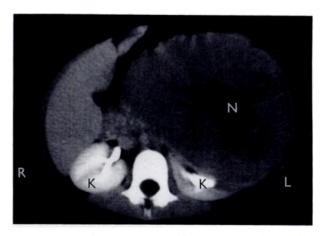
Computed tomography of the abdomen of a 5-year-old boy who has Wilms tumor. There is almost complete obliteration of the upper pole of the left kidney (K) by a large mass, apparently originating from this site. The mass has a large area of decreased attenuation, probably representing necrosis (N) in its center.
